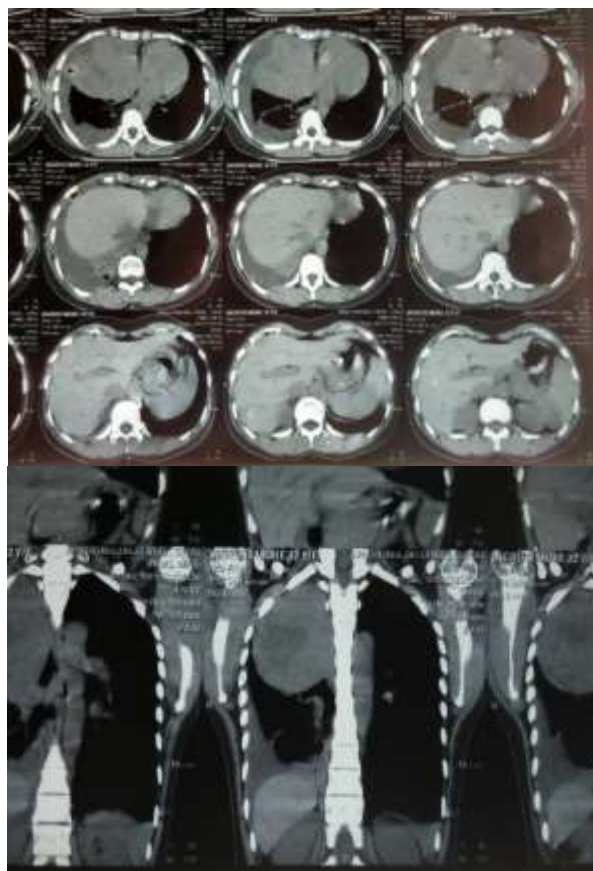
Contrast enhanced CT scan of thorax was done which showed a soft tissue density lesion in right upper lobe and middle lobe with internal necrotic area, involving mediastinal and costal pleuras and compressing right main bronchus as well as trachea, suggesting a picture of malignant mass.
